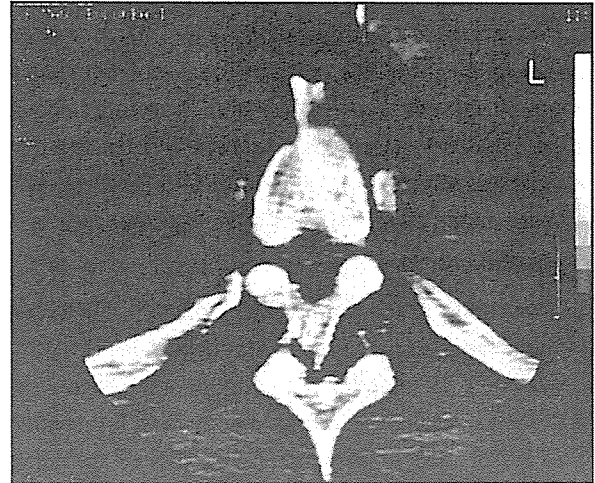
CT scan showing two dislocated vertebrae in the same place.
